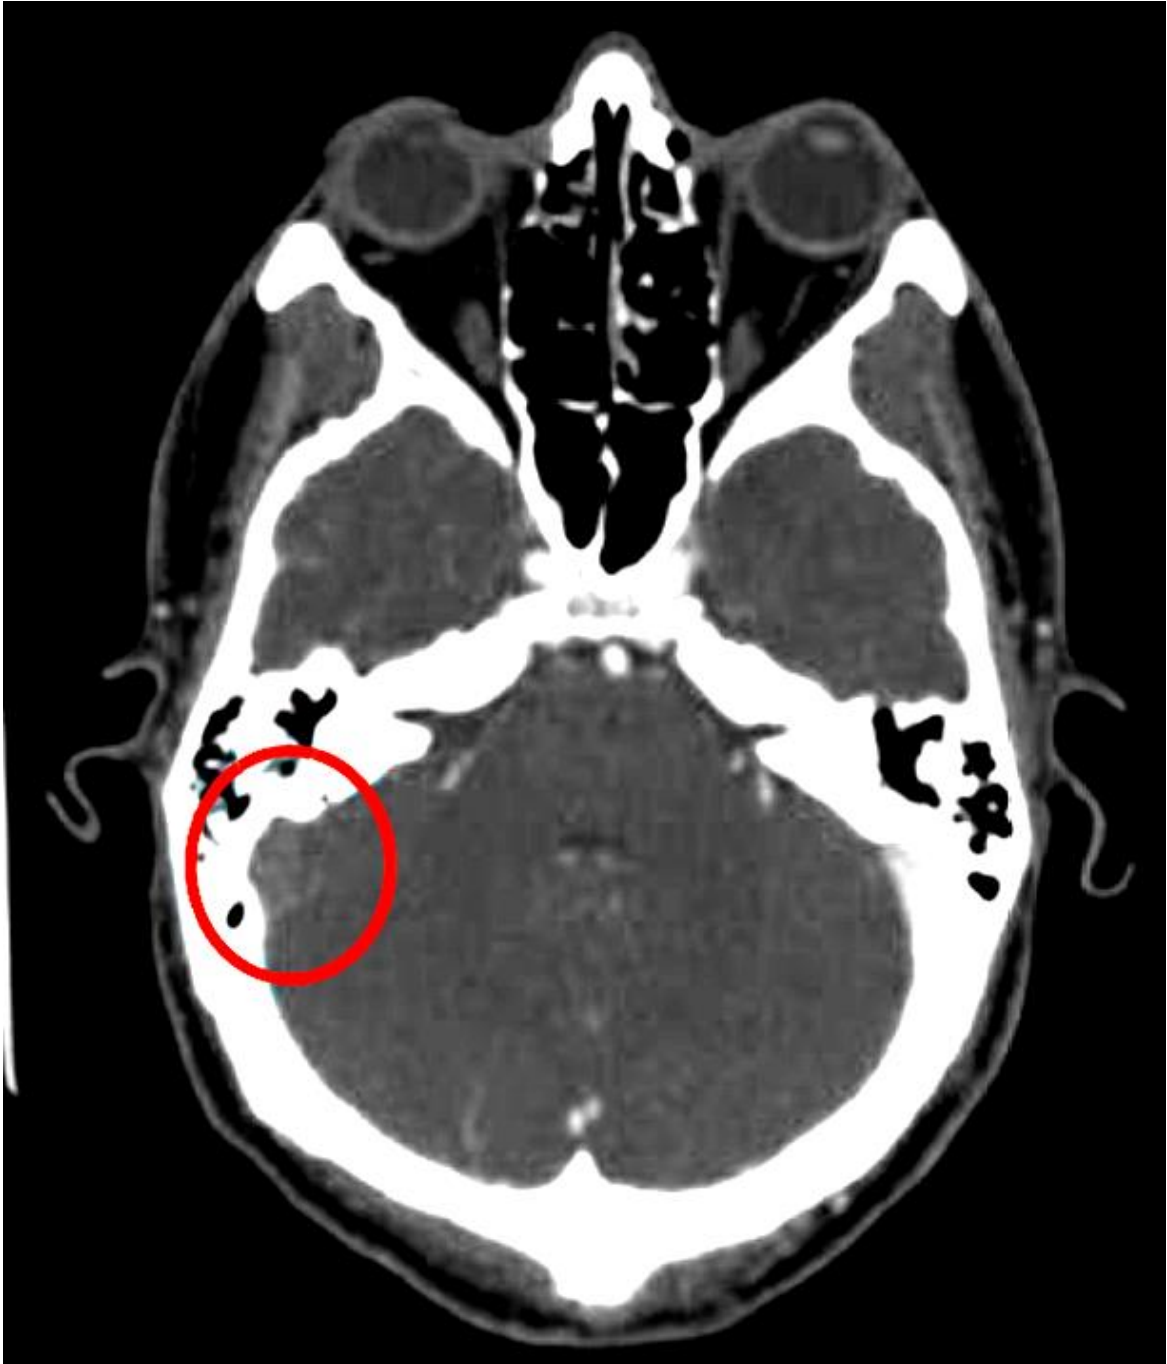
Axial contrast-enhanced CT image shows a filling defect in the right lateral sinus (circle)
